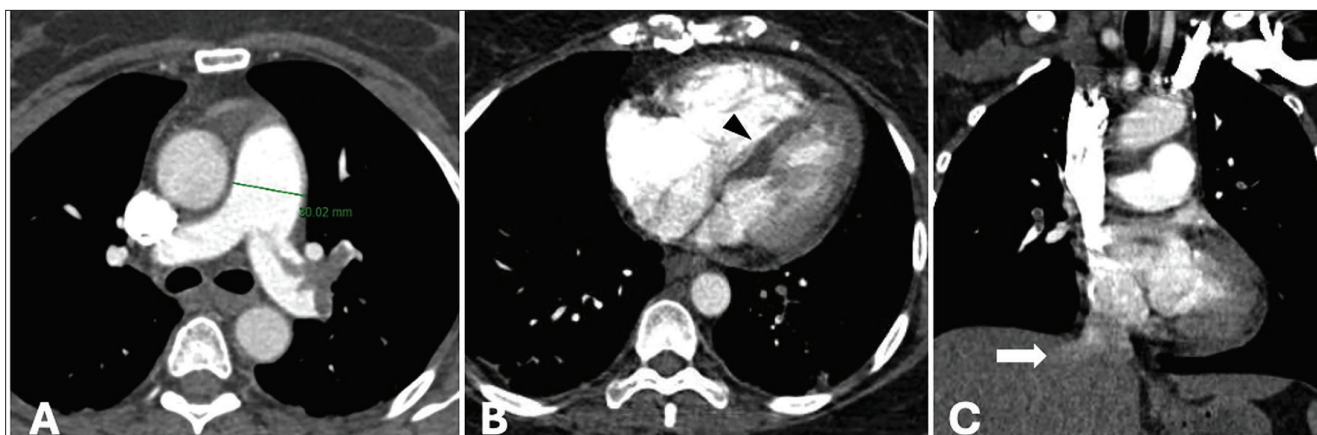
Pulmonary hypertension was suggestive on computed tomography pulmonary angiography with (A) enlargement of the pulmonary artery trunk, (B) dilatation of the right ventricle and flattening of the interventricular septum (arrowhead), and (C) reflux of the contrast media to the right hepatic vein (arrow).
